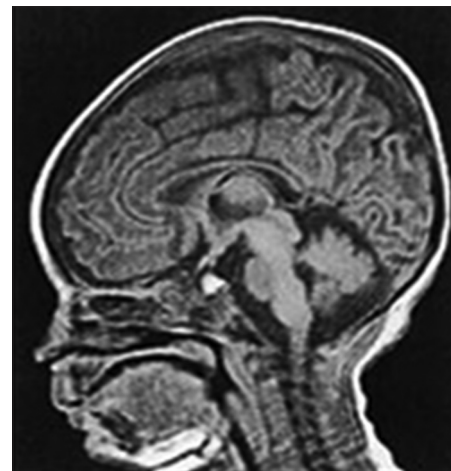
Magnetic resonance imaging of normal infant brains
